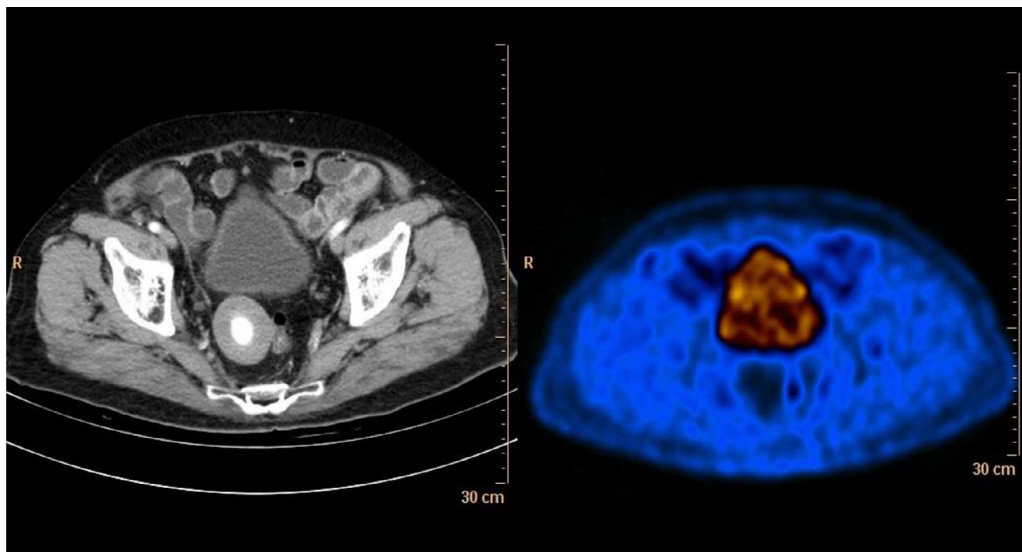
PET-CT of abdomen shows similar well-defined round to oval mass in the pelvis with absence of inflammation and normal wall of the rectum and sigmoid colon (a); PET CT fusion image shows absence of any FDG uptake (b).
